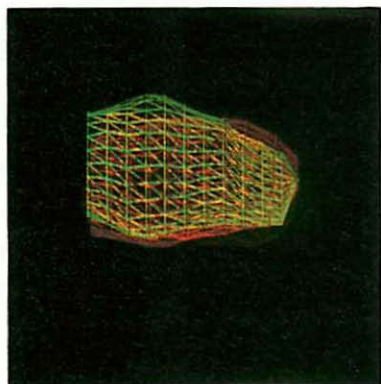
Relationship between SPECT (red) and MR (green) LV surfaces before registration.
